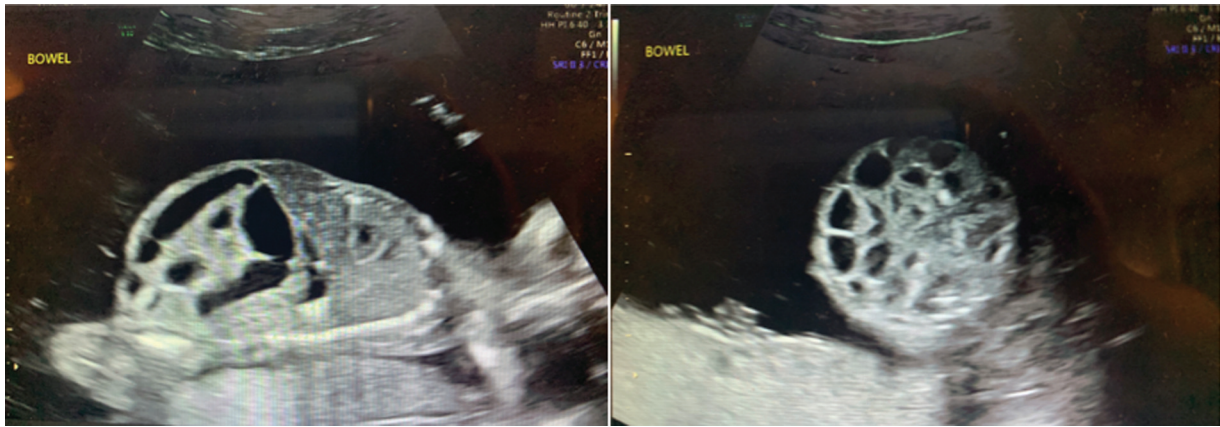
Antenatal ultrasound at 20 3/7 weeks showing diffusely dilated fetal loops of bowel.
